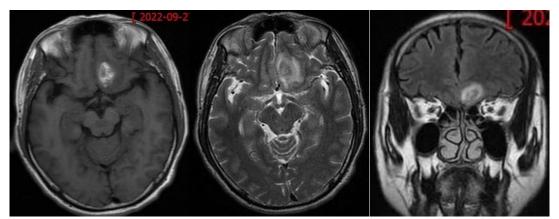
MRI image of cerebral hemorrhage (showing hematoma and perifocal edema)
